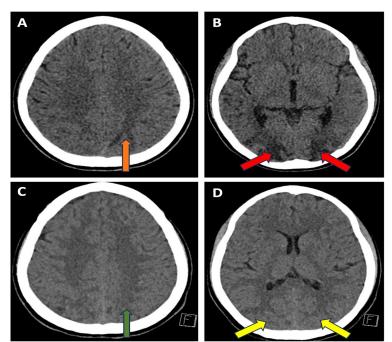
Non-contrast-enhanced computed tomography scan of the brain at presentation (above) and at five weeks follow-up (below): Non-contrasted computed tomography scan of the brain at presentation showed ill-defined white matter hypodensity at the left posterior parietal lobe (orange arrow) (A) and bilateral occipital lobe (red arrow) (B). A repeated computed tomography of the brain at five weeks follow-up showed patchy hypodensity on the left posterior parietal region (green arrow) (C) and hypodensity at the bilateral occipital region (yellow arrow) (D).
